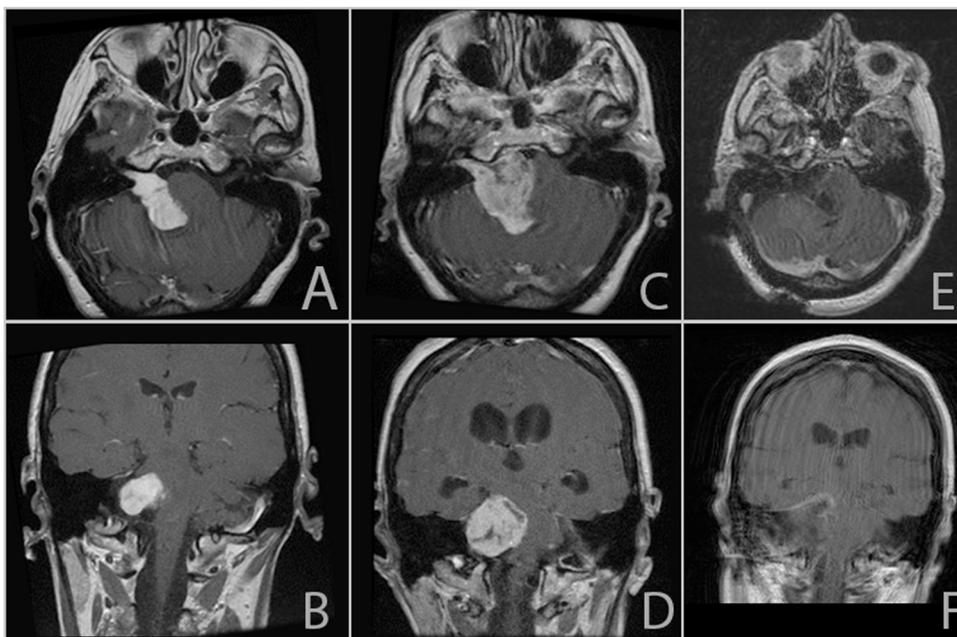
T1-post contrast MRI scans. Axial and coronal studies from 3 years prior to presentation (A,B), preoperative (C,D), and postoperative after near total resection (E,F). Significant increased growth is noted from the last stable scan compared to the preoperative scan indicating a significant change in the tumor behavior.
